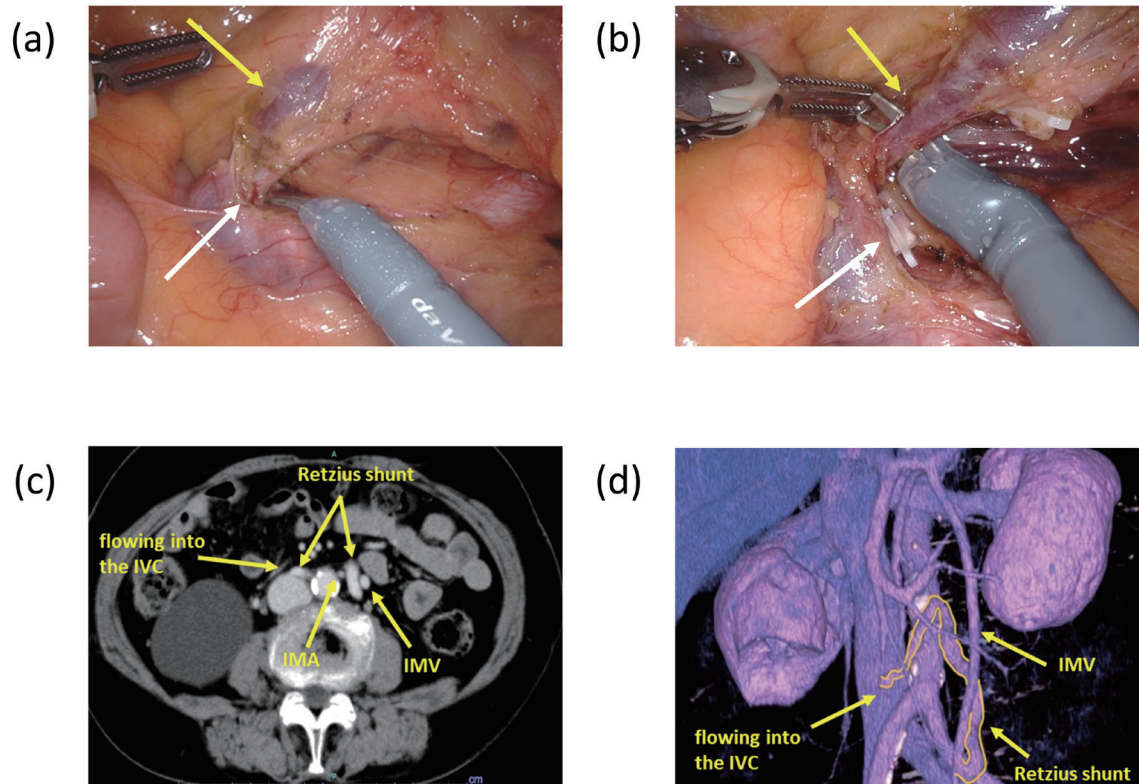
Intraoperative findings. (a, b) Intraoperative findings indicate a dilated vein (yellow arrow) outside the IMA (white arrow). (c, d) Contrast-enhanced CT (c) and 3D CT (d) show the Retzius shunt crossing the IMA and the IMV flowing into the IVC.
